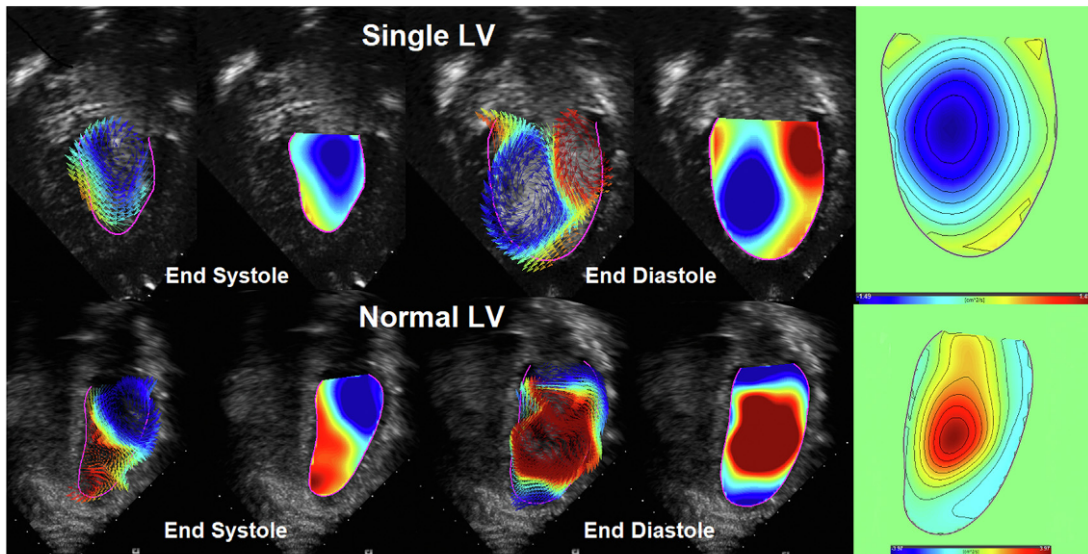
Representative echocardiographic PIV derived velocity fields and vorticity in the SLV (*top*) and normal LV (*bottom*) at end systole and end diastole. For each representative case, images are paired, with the PIV-derived velocity field image on the *left* and vorticity map on the *right* in end systole and end diastole, as indicated. Shown on the *far right* is the average vorticity throughout the entire cardiac cycle. For all vorticity maps, *blue* indicates a counterclockwise rotational velocity, while *red* indicates a clockwise rotational velocity. For all *arrows*, the *arrow tail* emanates from the corresponding pixel. As such, *arrows* that appear just outside the boundary result from velocities of pixels inside the boundary.
